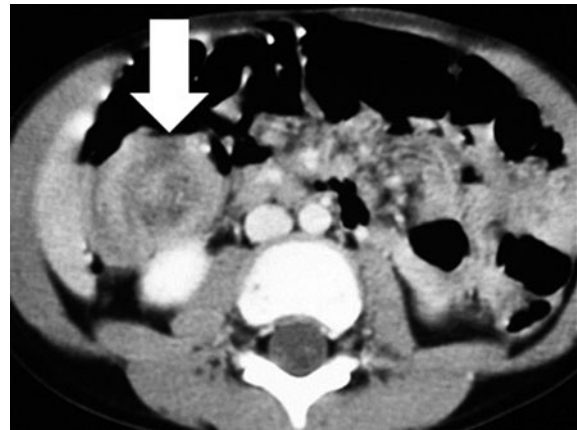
Intussusception in a 2-year-old-female with abdominal pain. Axial contrast-enhanced CT image shows a right lower quadrant mass forming a target appearance with alternating layers of bowel wall and mesenteric fat (*arrow*). The target appearance is due to the infolding of the small bowel (intussusceptum) into the colon (intussusciens)
